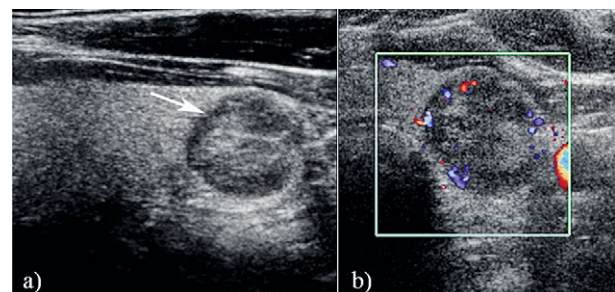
Adenoma. A 53 year old female presented for follow up US for thyroid nodule. Sagittal US (a) through the right lobe showed a hypoechoic nodule with no internal calcifications and with minimal internal vascularity on transverse color Doppler image (b).
